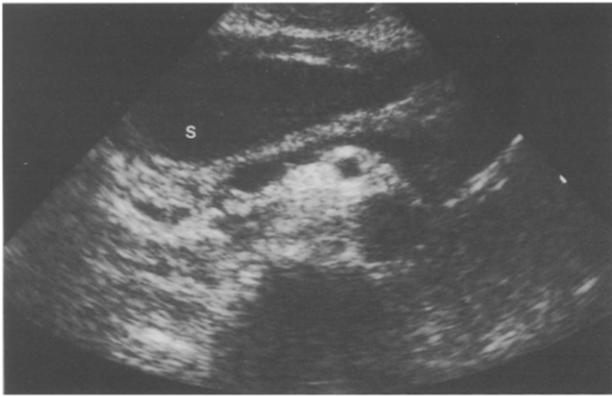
Ultrasound image (transverse plane) of the pancreas after oral administration of simethicone-coated cellulose contrast, in the same patient, showing the large acoustic window provided by the contrast agent filled stomach (S). The pancreatic head, body, the splenic vein, and the superior mesenteric artery are depicted well.
